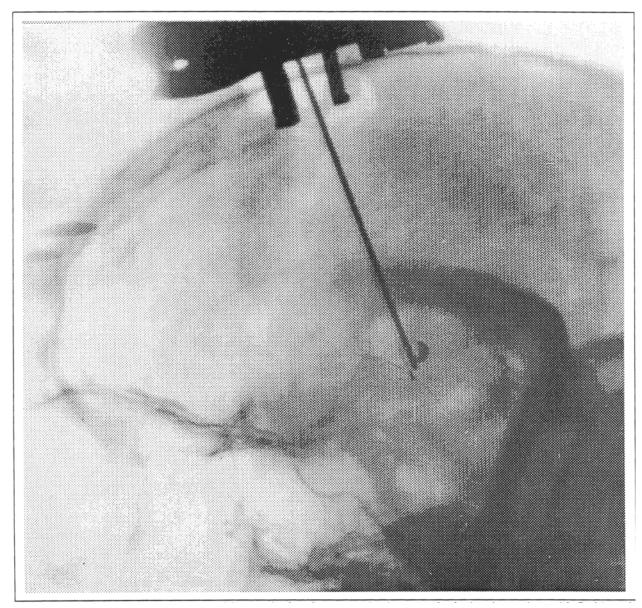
Transplantation of a mixture of human fetal and xenogeneic tissue to the brain of a patient with Parkinson's disease. Roentgenogram of atraumatic formation of cavity prior to tissue implantation.
